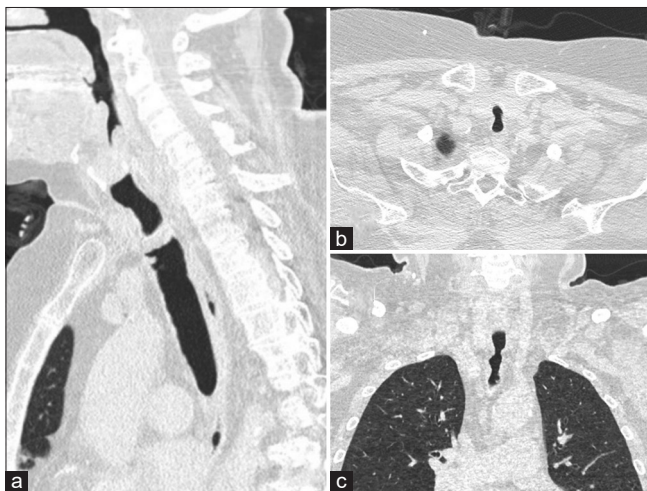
Chest CT scan image; CT sagittal (a), axial (b), and coronal (c) views showing the tracheal stenosis
